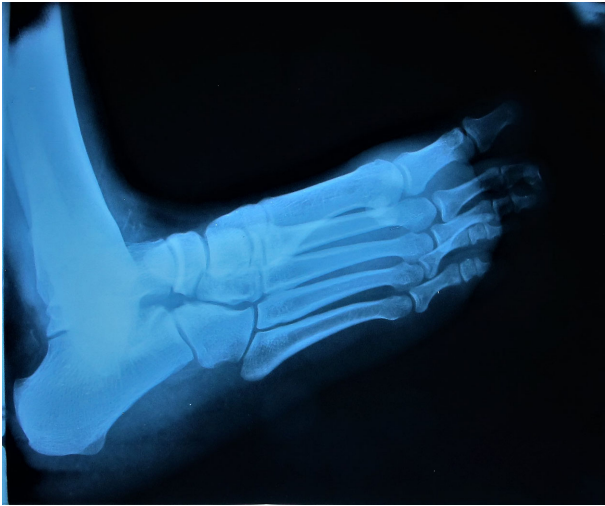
X-ray of the left foot in a lateral view showing no apparent abnormality.
